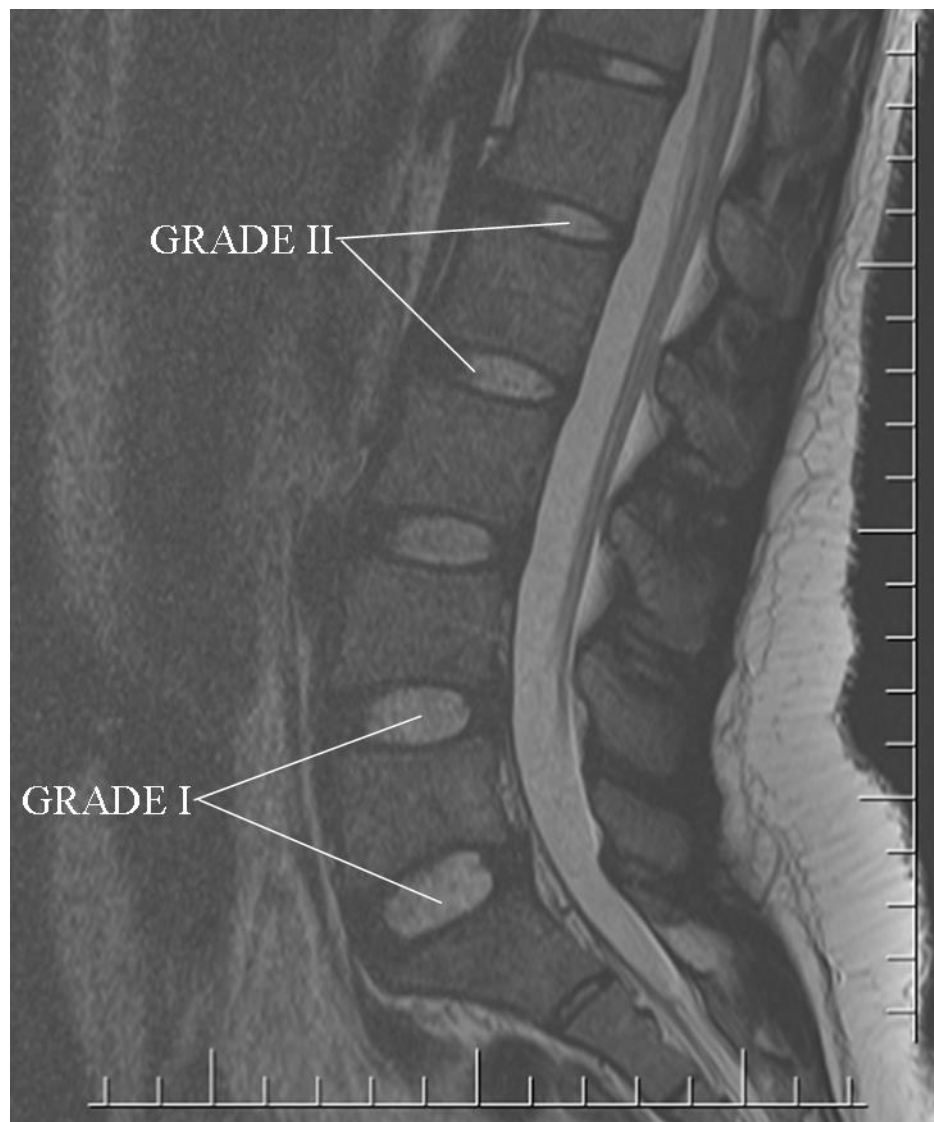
MRI image of lumbar spine showing Pfirrmann's disc degeneration grade I (homogenous disc with bright hyperintense white signal intensity and normal disc heights) and grade II (inhomogeneous disc, hyperintense white signal with horizontal grey bands). Magnification: 0.7 X
